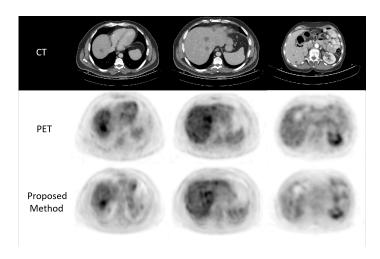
Sample results of the predicted PET using our method compared to the real PET with the corresponding CT images.
